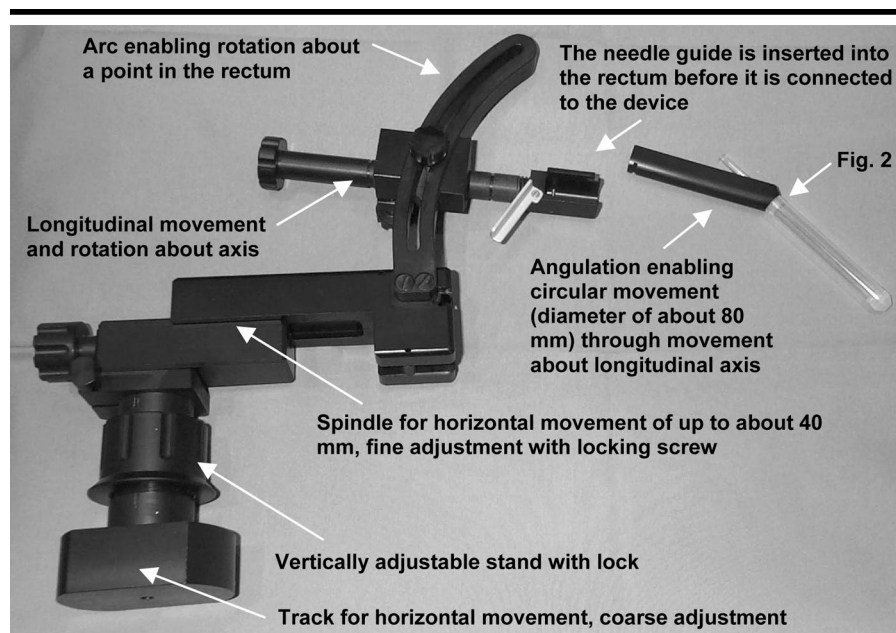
Photograph shows biopsy device without base plate and cushion for patient positioning. The stand is variable in height and rests on a base plate containing a track that enables movement of the device along the longitudinal axis of the MR unit. Except for small parts such as screws, the device is made of synthetic materials that are fully compatible with MR imaging.
